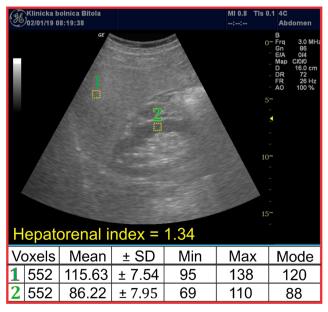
Analysis of a sonogram by ImageJ software and calculation of the hepatorenal index
